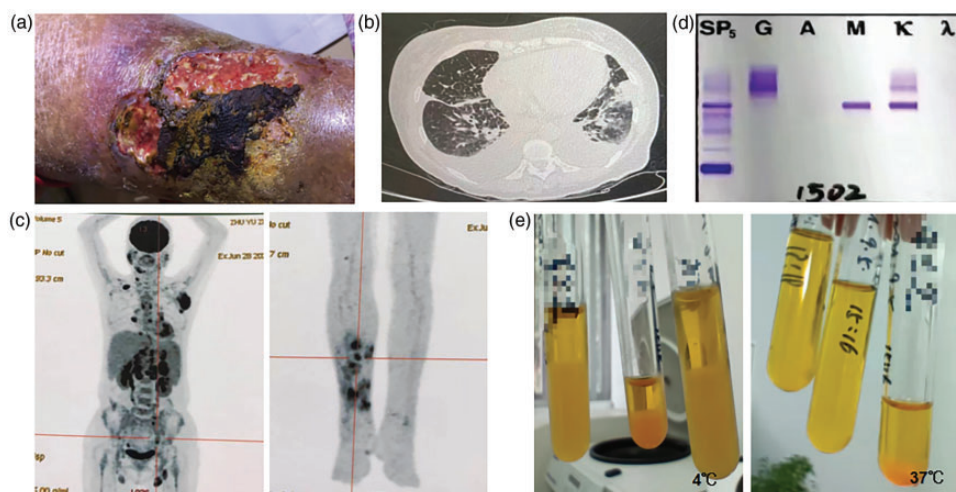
The clinical features of the patient. (a) Ulceration, scabs, hyperpigmentation, and inflammation occurred simultaneously on her right lower leg. (b) The lung computed tomography (CT) scan showed interstitial changes and pleural effusion in both lungs. (c) 18F-fluoreodeoxyglucose positron emission tomography/computed tomography (18FFDG-PET/CT) revealed multiple highly metabolically active lymph nodes and skin on the right lower leg. (d) The results of immunofixation electrophoresis analysis of the serum. A small cluster of monoclonal bands can be seen in the far-left lane. The lanes labeled as G, M, and κ demonstrated a monoclonal IgM- κ band and polyclonal IgG- κ band, respectively. The lambda anti-sera were performing normally and the tests were conducted using serum and urine separately, with equivalent results observed and (e) the cryoglobulin testing showed positive results and the cryocrit was approximately 65%. Specifically, 20 mL of blood was drawn into collection tubes that were prewarmed to 37°C without anti-coagulants. After clotting at 37°C for 30 minutes, the serum was separated by centrifugation at 37°C, placed into a graduated tube, and refrigerated at 4°C to allow cryoglobulin precipitation after 24 hours.
